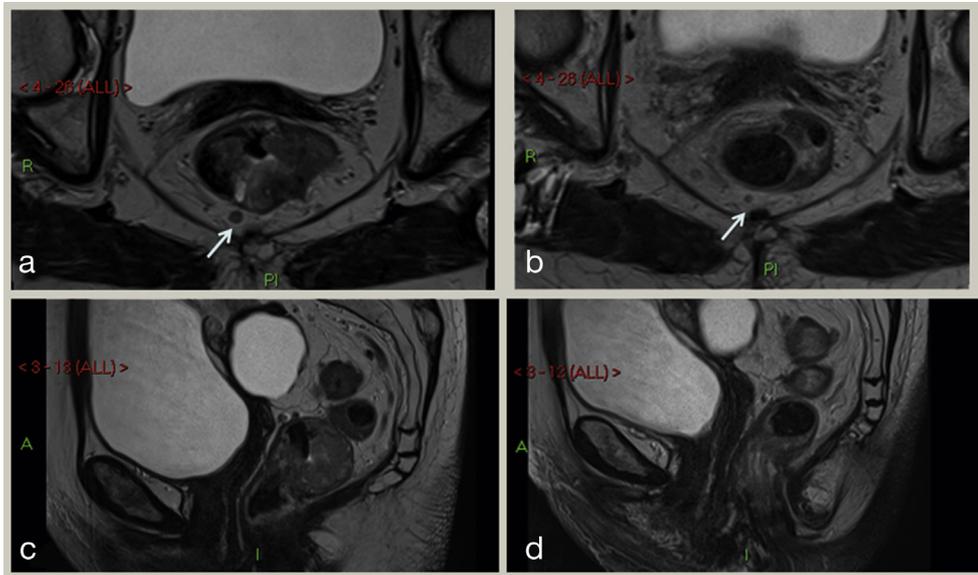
MRI of rectal cancer before long-course chemoradiation. (a, c) showing mesorectal lymph node (arrow), which is reduced in size after treatment (b). Sagittal sections show an overall reduction in tumour bulk from before (c) to after (d) treatment. Images courtesy of Dr Stephen Glancy, Consultant Radiologist, Western General Hospital, Edinburgh, UK.
